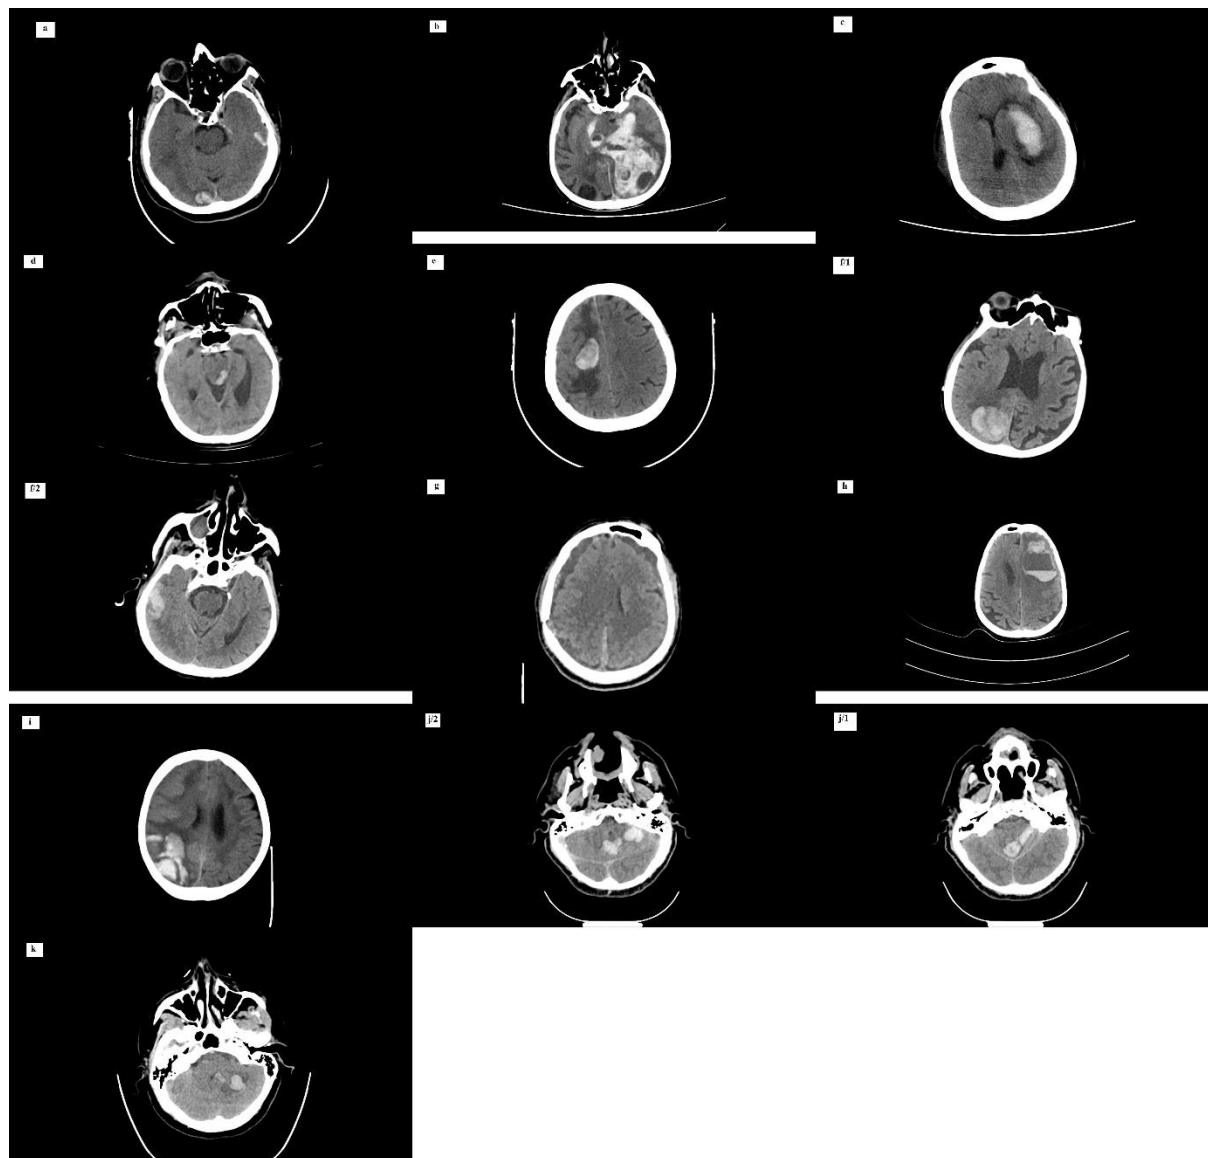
CT head for all COVID-19 patients. Cases 1-11, a-k, respectively.
